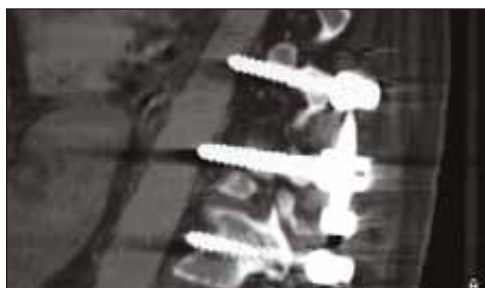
Magnetic resonance imaging reveals screws impinging on the aorta.
